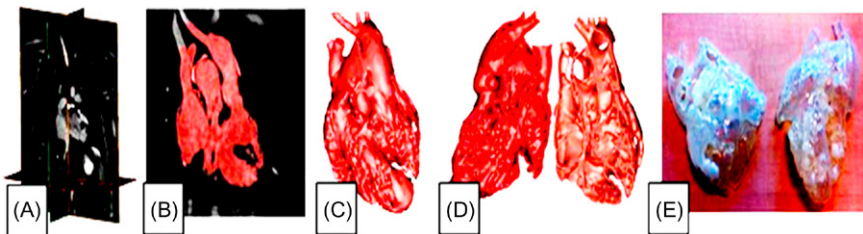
Process to create anomalous heart model [22]. (A) Magnetic resonance images of the heart; (B) Segmentation of the lumen; (C) 3D reconstruction of the blood volume; (D) Hollowed and sectioned view of the heart; (E) 3D printed flexible heart. © Schrot et al.; licensee BioMed Central Ltd. 2014 under the terms of the Creative Commons Attribution License.
